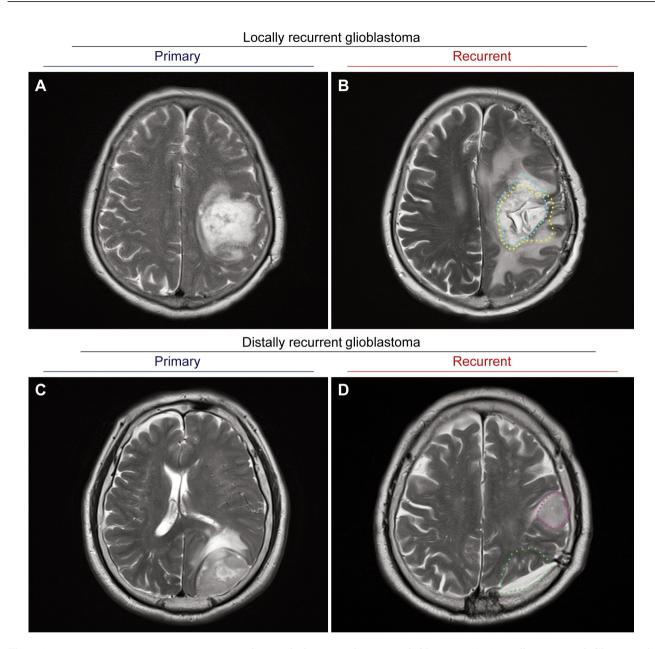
Representative magnetic resonance images showing the locations of recurrent glioblastomas. (A-B) Locally recurrent glioblastoma. The location of primary tumor (outlined by yellow dots) is nearly identical to that of the recurrent tumor (blue dots). (C-D) Distally recurrent glioblastoma. The location of recurrent tumor (purple dots) is different from that of primary tumor (green dots).
